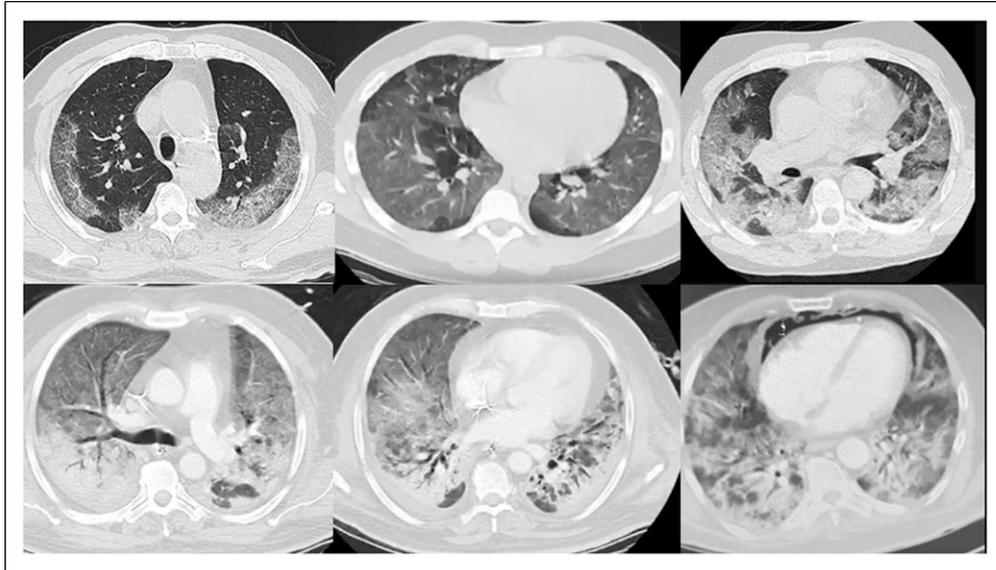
Progression of CT features of COVID-19 organizing pneumonia.
